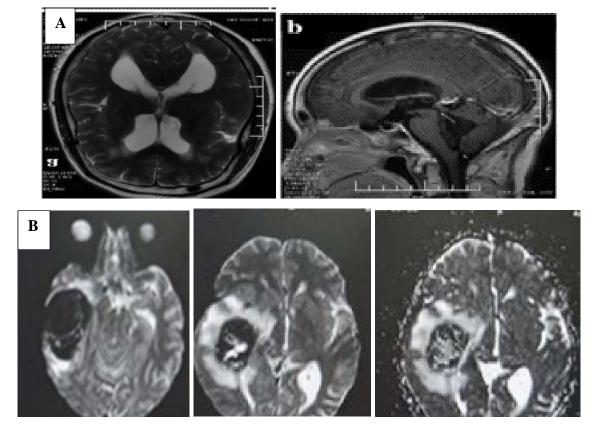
Magnetic resonant imaging (MRI) brain of case 1 pre-and post-operative. A: MRI brain imaging (preoperative) showing acute supra-tentorial and infra-tentorial hydrocephalic changes with mild tonsillar herniation. B: right temporal large space occupying lesion with two components one has a dural base eliciting intermediate to low T1 signal, intermediate T2 and FLAIR signal with post contrast enhancement measuring 2x3.3x3.7 cm, while the medial aspect shows hematoma and surrounding vasogenic brain edema.
